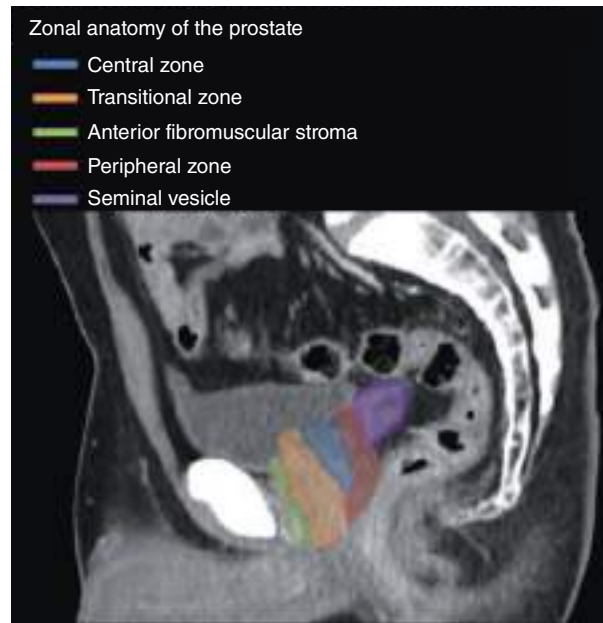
Sagittal contrast-enhanced MPR CT image (portal venous phase).
